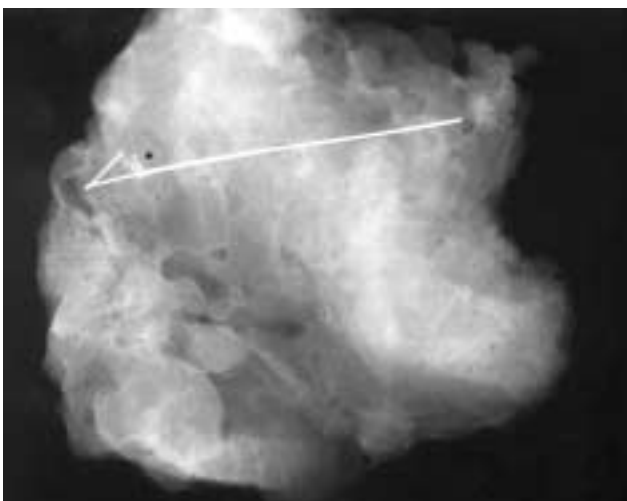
Radiography of the surgically excised lesion with hook-wire in place. Note the microcalcifications (asterisk).
